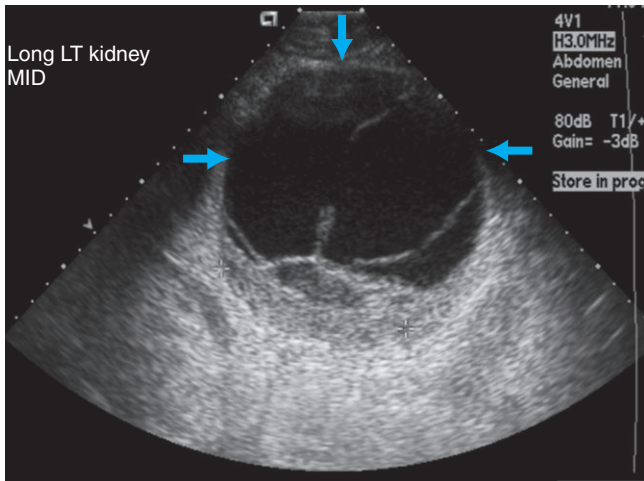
Ultrasound images demonstrate a subcapsular anechoic fluid collection (arrows) with septations causing mass effect on the underlying kidney in this patient with chronic subcapsular hematoma, which has now completely liquefied.
